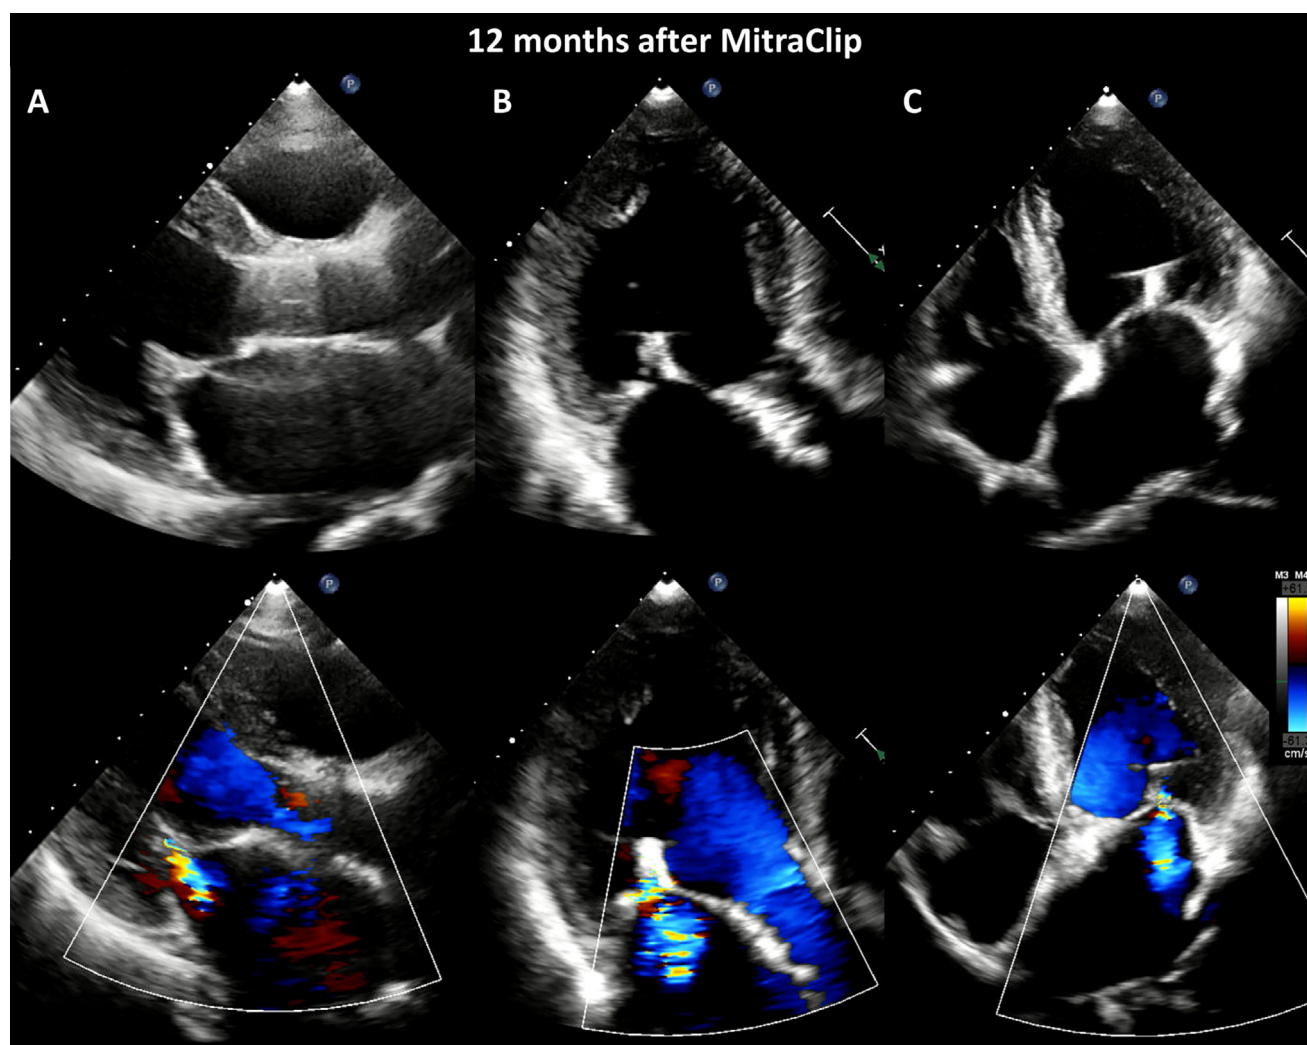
Transthoracic echocardiography and color Doppler echocardiography [(A) parasternal long axis view, (B) apical three-chamber view, (C) apical four-chamber view] at 12 months after MitraClip® deployment. No significant recurrence of mitral regurgitation was observed (grade 1+).
